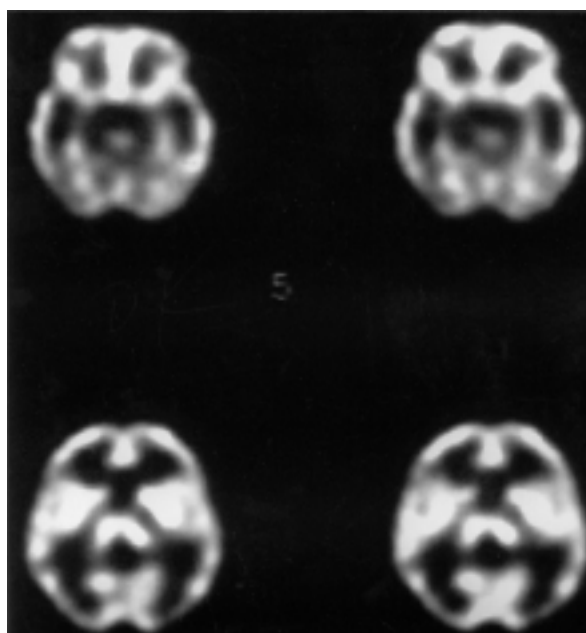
Demonstration of negative brain SPECT images, no definite perfusion defect was found
